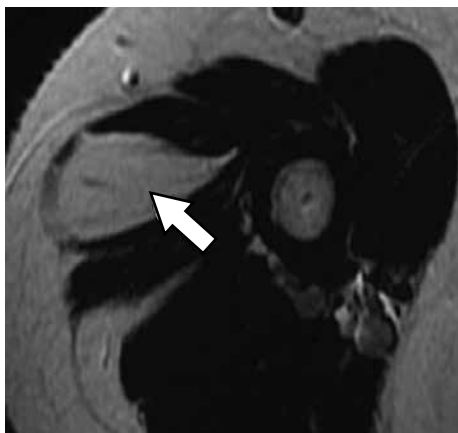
MRI. T1-weighted axial sequence. a well defined lesion, located in the soft tissues of the right arm with extension towards the deltoid muscles, with high T1 signal and loss of signal in the fat saturation sequence, corresponding to lipoma (arrow).
